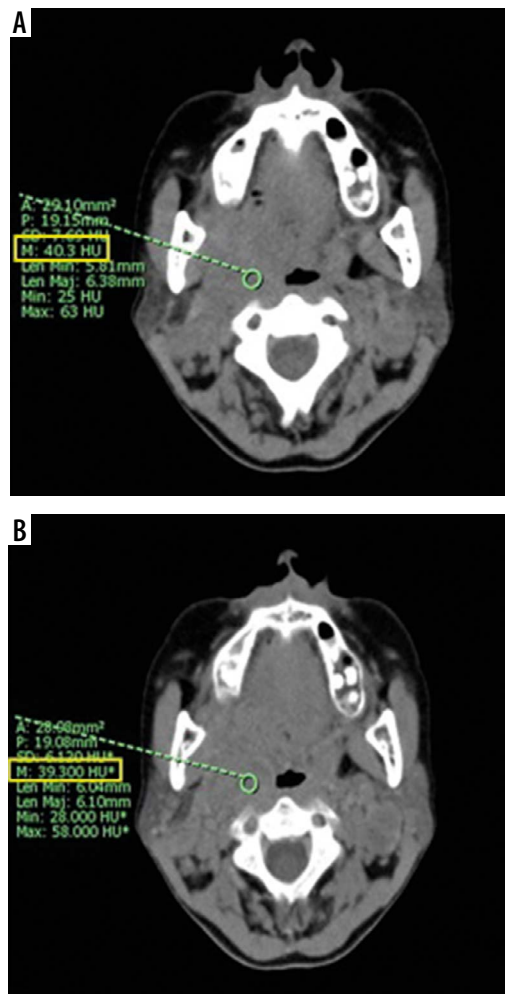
A 44-year-old woman with CA soft palate. Comparison of computed tomography attenuation values of the tumor at the same level between (A) axial true non-contrast image – 40.3 HU and (B) axial virtual non-contrast image – 39.3 HU
